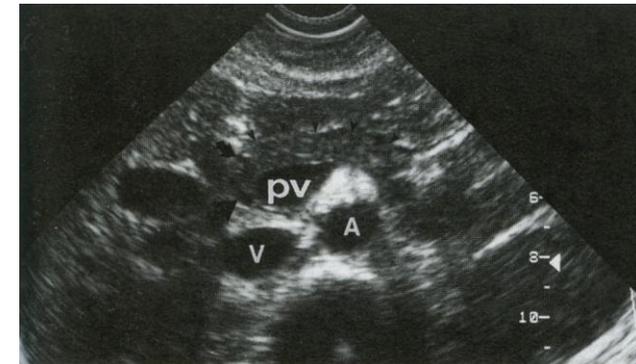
Transverse sonogram of normal pancreas. The normal pancreatic parenchyma (arrowheads) is well seen surrounding the portal vein (pv). The right lateral margin of the pancreatic head is posteriorly bordered by the common bile duct (arrow) and anteriorly by the gastroduodenal artery (curved arrow). (A = aorta, V = inferior vena cava.)
